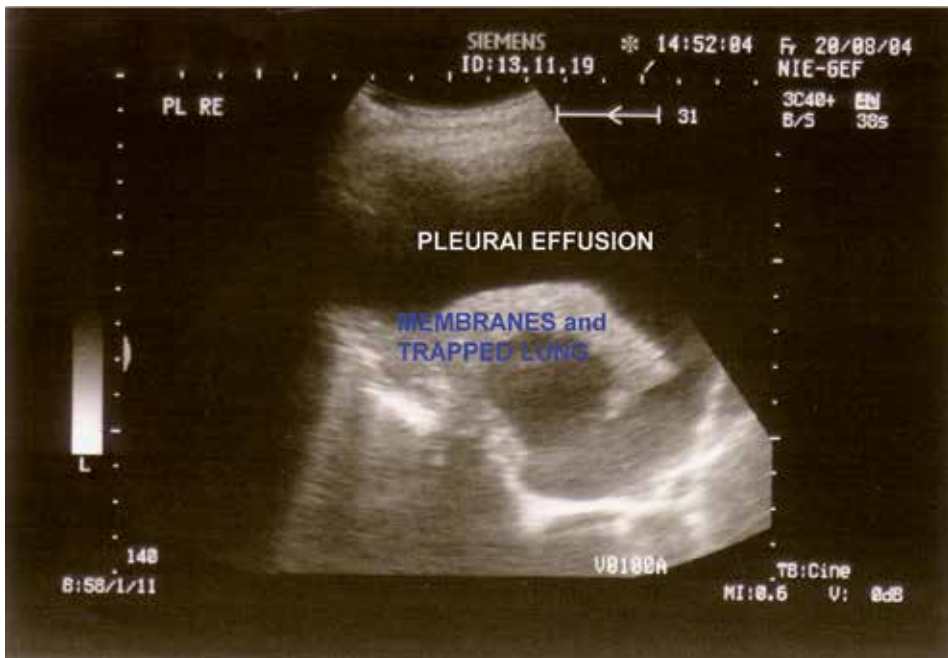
Ultrasound detection of inflammatory visceral membranes and consecutively trapped lung in pleuritis exudativa tuberculosa
